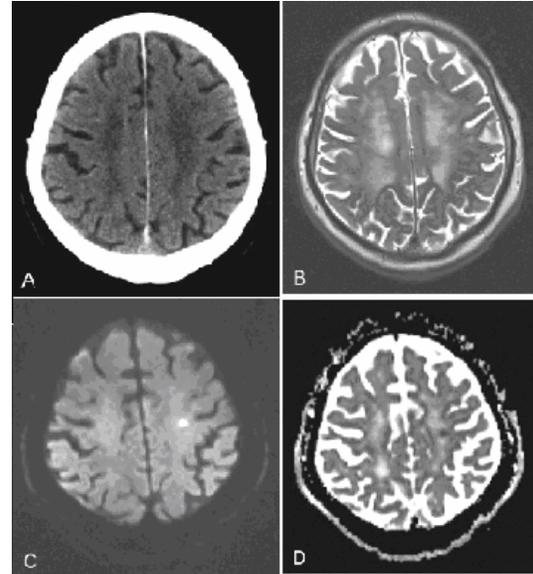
(A–D): 85 year old man with coronary artery disease presented to acute stroke unit 18 hours after the onset of right sided hemiplegia and dizziness. CT (A) showed wide spread white matter changes. MRI performed 2.5 days after ictus showed severe confluent hyperintensity of the white matter. T2-weighted images (B) could not distinguish a separate acute ischemic change. DWI and ADC (C, D) revealed an acute lacunar cortical and subcortical infarction near the precentral gyrus.
